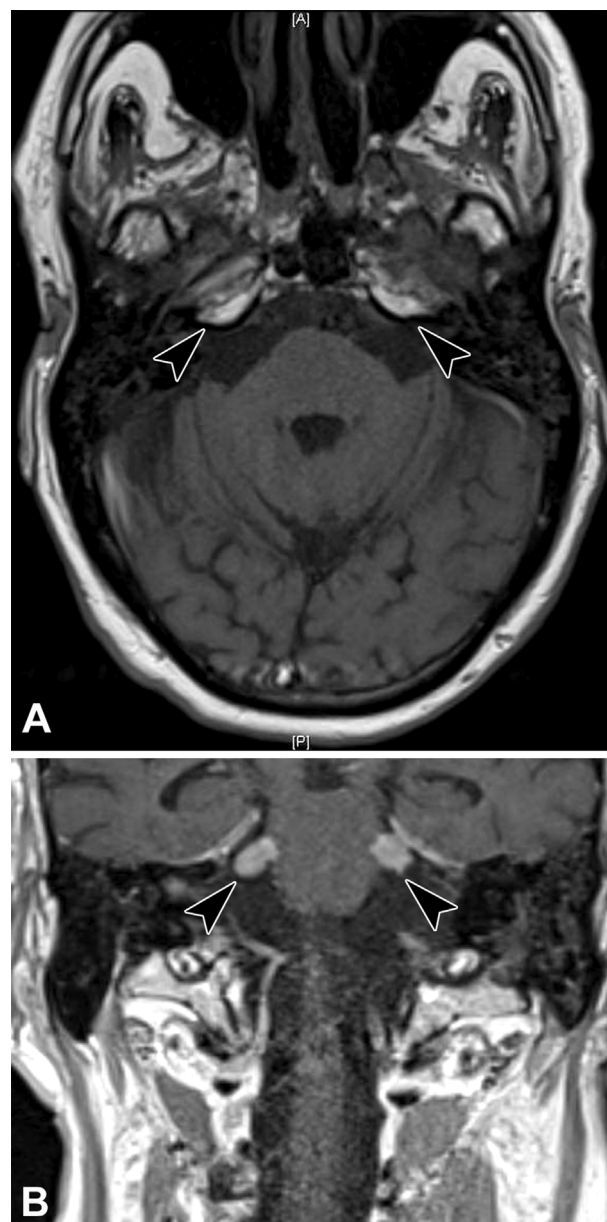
Magnetic resonance images two weeks prior to death. Two weeks prior to death, axial (A) and coronal (B) T1 weighted magnetic resonance images following gadobenate dimeglumine administration revealed abnormal enhancement and enlargement of cranial nerves V (arrowheads).
